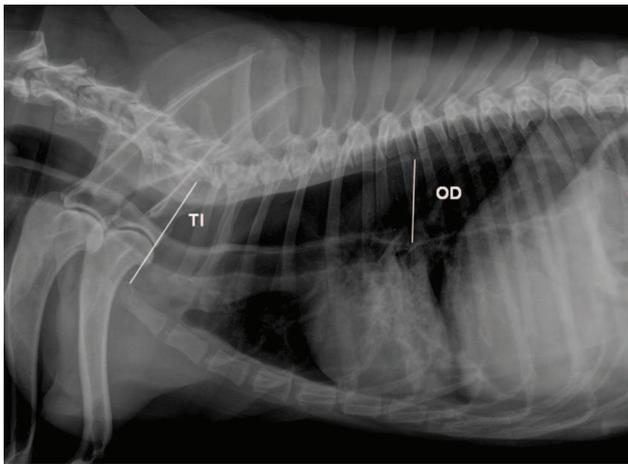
Radiographic measurement technique as proposed by [Wray and Sparkes \(2006\)](#). The oesophageal diameter (OD) was measured in each radiograph at its widest point, perpendicularly to the oesophageal longitudinal axis, at the level of its luminal surface. The thoracic inlet (TI) was also measured in the same radiograph, from the ventral aspect of the vertebral column at the mid-point of the first rib, to the inner aspect of the manubrium at the point of narrowest diameter of the TI. The relative OD (ROD) was calculated, using the OD/TI ratio
